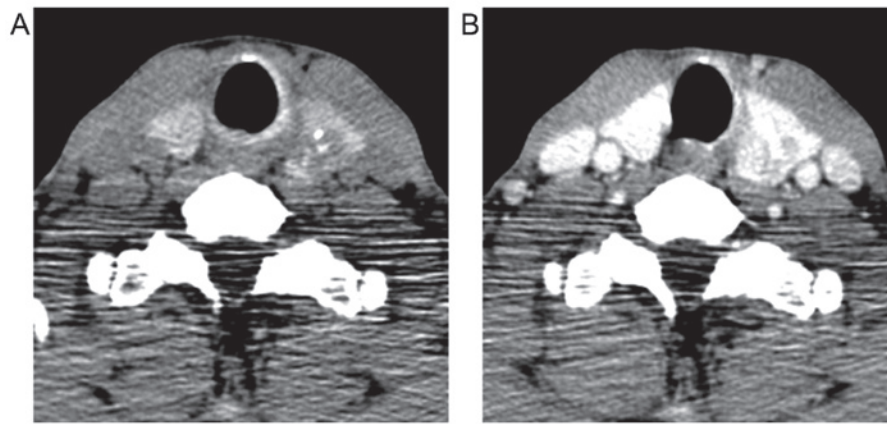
CT images on thyroid level. (A) Soft tissue CT image shows left lobe was enlarged. (B) CE-CT demonstrated lesion with calcification inside, lesion showed non-uniform low concentration with approximately 28 mm in diameter size.
